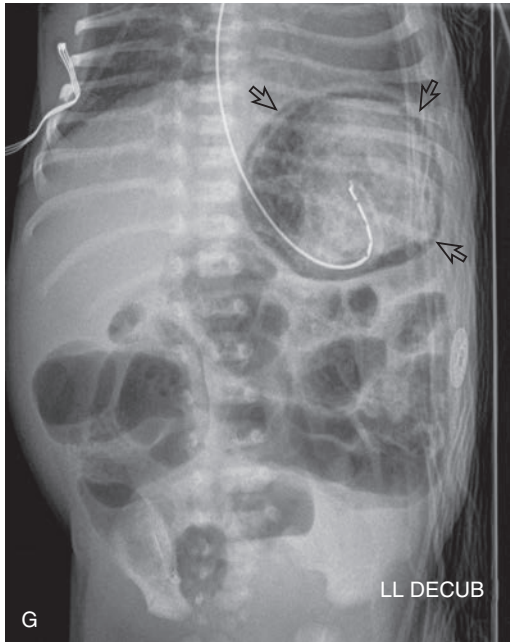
cont'd. G, Gastric pneumatosis intestinalis is a rare finding for NEC, but when present, it indicates a grave prognosis. A lateral decubitus radiograph demonstrates air outlining the stomach (arrows) and not collecting in the nondependent portion, confirming intramural, not intraluminal, air.
